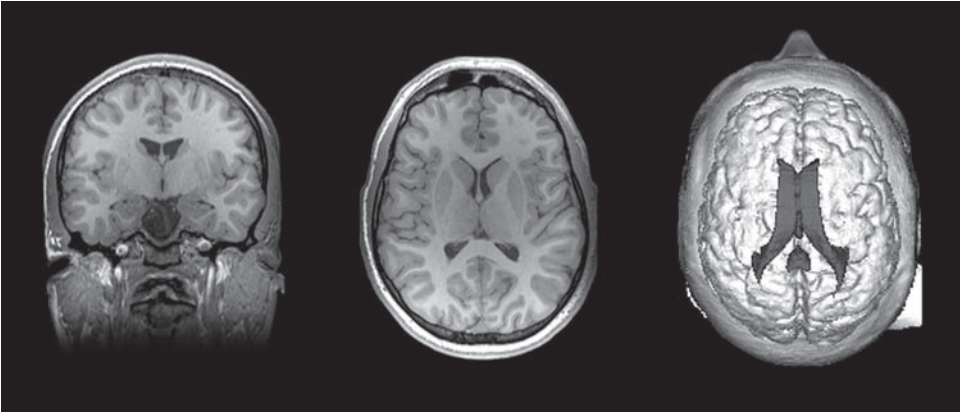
MRI is depicted in the coronal plane (left), axial plane (middle), and top view of a three-dimensionally rendered brain highlighting the ventricles (right). Regardless of the view, note the general symmetry of the brain when one side is compared to its counterpart in the opposite hemisphere. Because of the closeness with which one hemisphere mirrors the other, features that show up in one hemisphere and not the other can be signs of underlying pathology.
